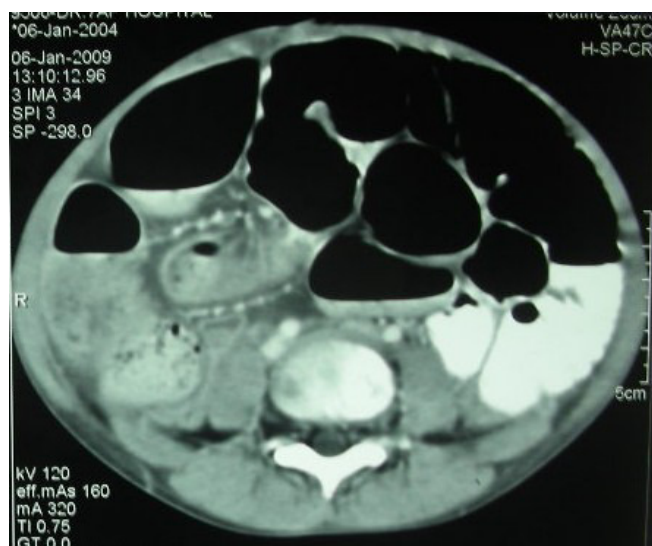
Abdominal CT showing stretched mesenteric vessels along with dilated small bowel loops.
